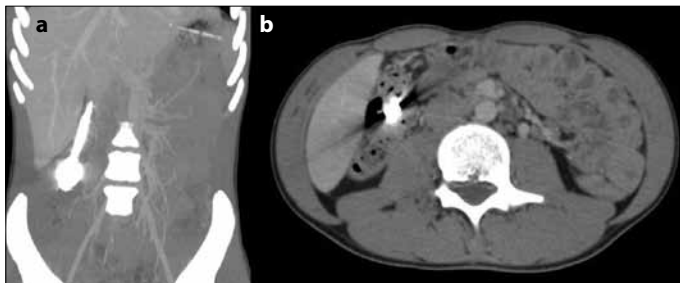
a, b. Coronal CT maximum intensity projection (MIP) and axial MIP images show vertical localized metallic foreign image and artifacts in the junction of the ascending colon and cecum
